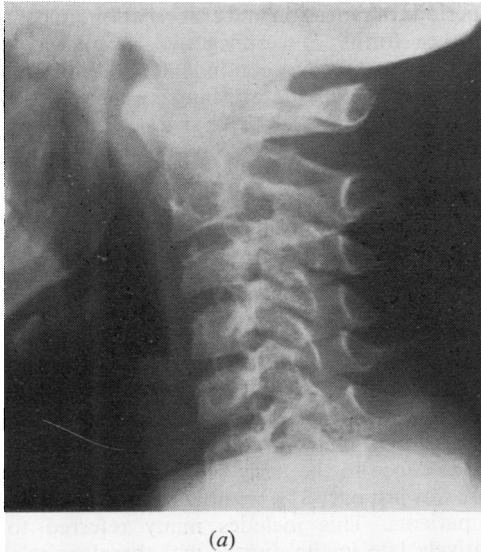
X-ray of cervical spine taken one year after onset of disease (a) showing straightening with some blurring of apophyseal joints and 7 years later (b) note growth has been resumed but there is bony fusion of apophyseal joints 2/3 and narrowing of the disc space between the 2nd and 3rd vertebrae.
